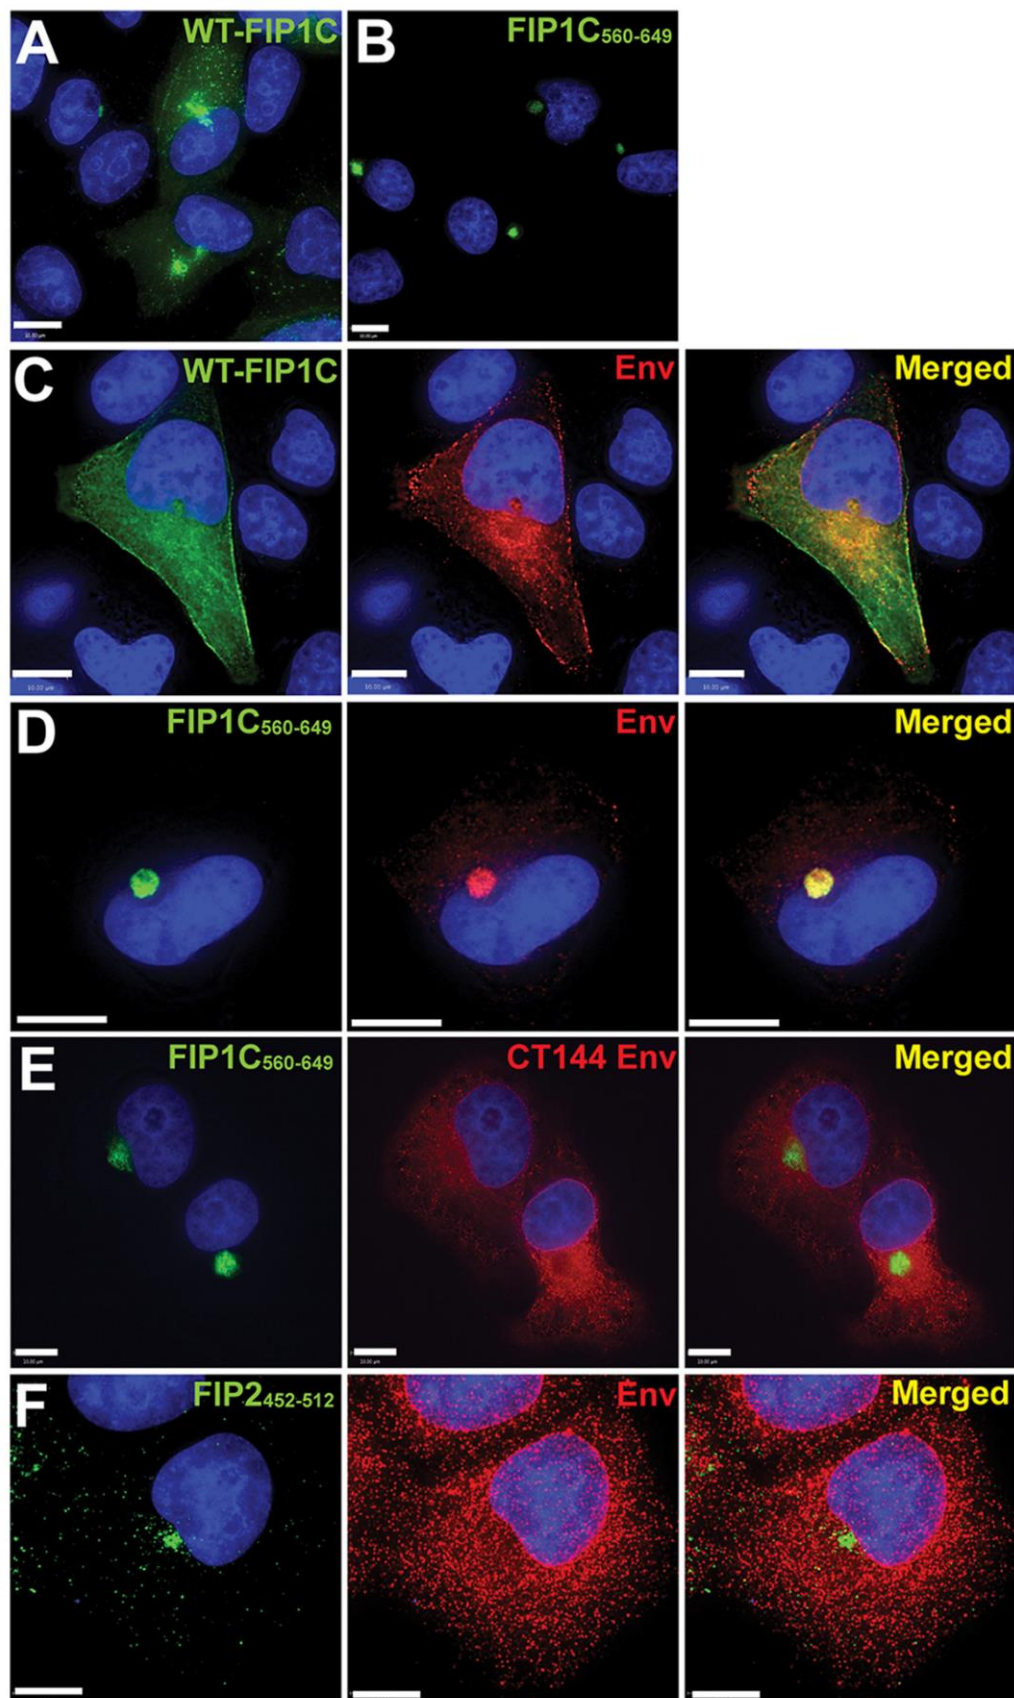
FIP1C₅₆₀₋₆₄₉ sequesters Env in a perinuclear compartment in a CT-dependent manner.
